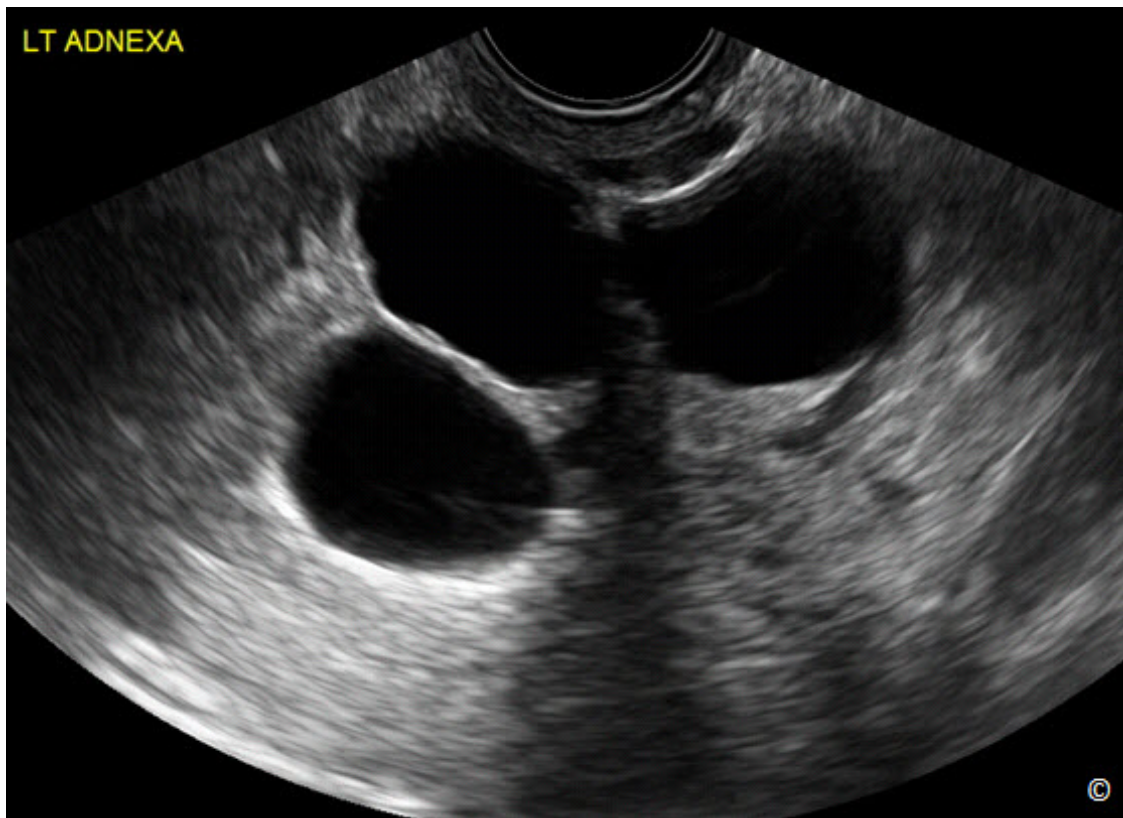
Transvaginal ultrasound of a hydrosalpinx. Note the presence of a tubular structure with thin walls and multiple septations.
